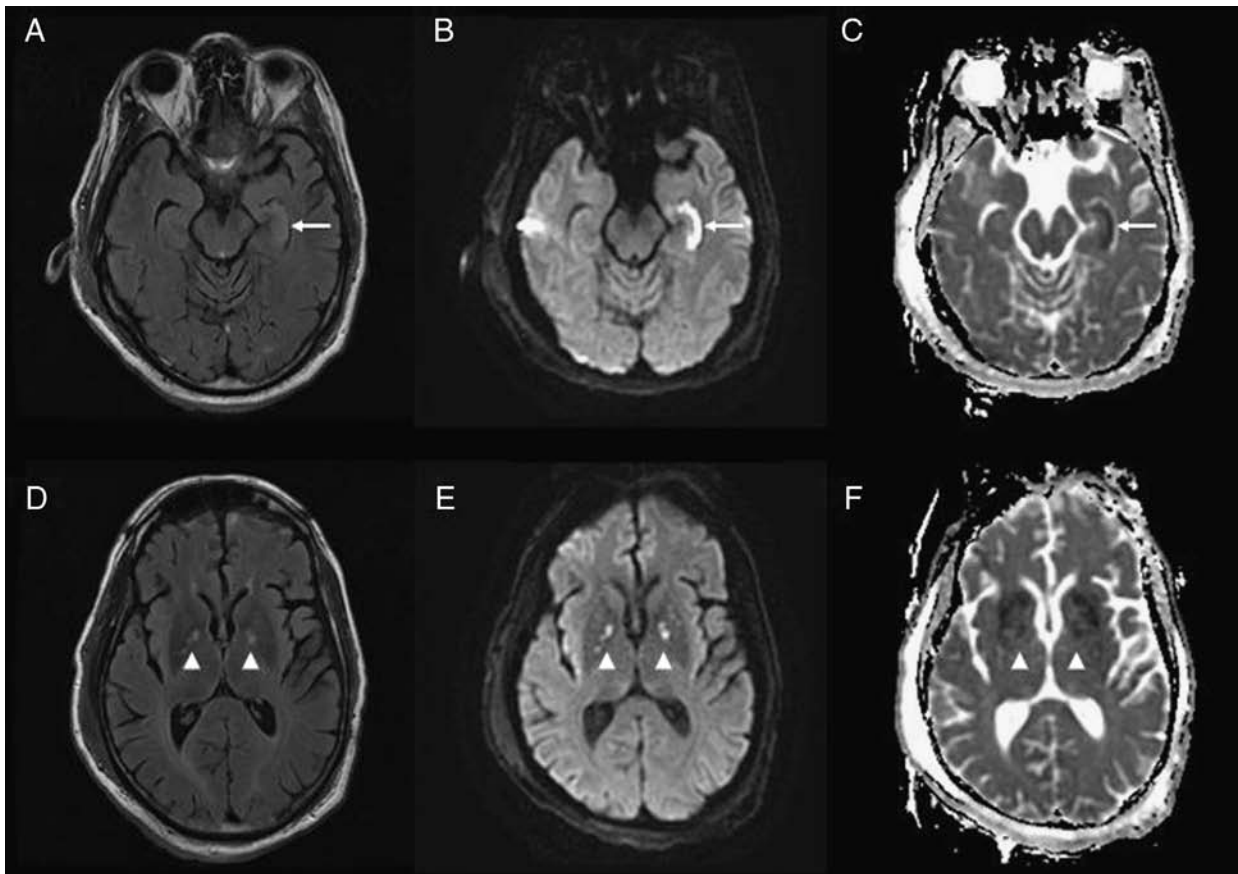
Magnetic resonance imaging without contrast of the brain. Axial T2 fluid-attenuation inversion recovery (FLAIR) (A, D), diffusion-weighted imaging (B, E), and apparent diffusion coefficient maps (C, F) at the level midbrain (A–C) and basal ganglia (D–F) show T2 prolongation and restricted diffusion within the left hippocampus (arrows) and multiple punctuate areas within bilateral globi pallidi and putamina (arrowheads), likely because of acute-subacute ischemia given the history of presumed prolonged hypoxic-ischemic episode.
